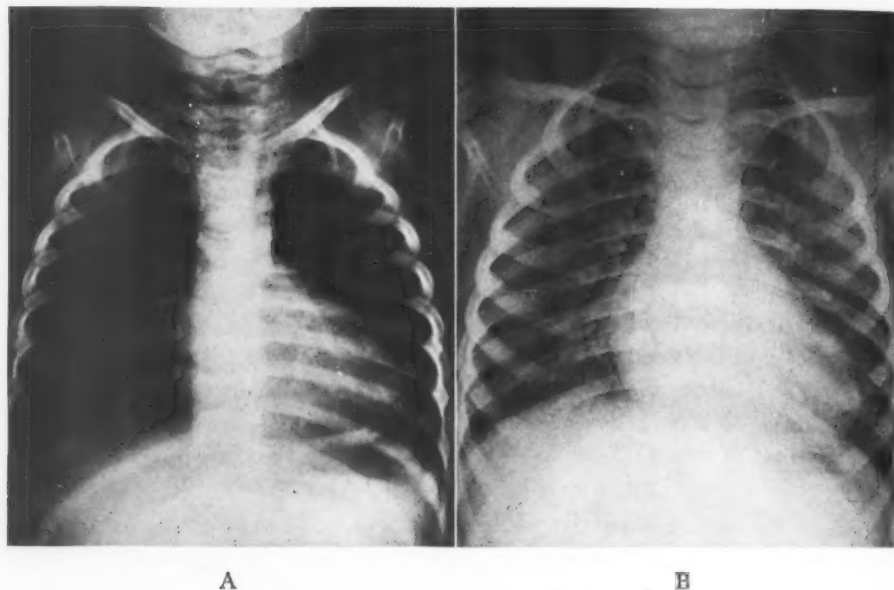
A. Preoperative roentgenogram of first patient, D. S., to have an aortic-pulmonary anastomosis, September 13, 1946.
